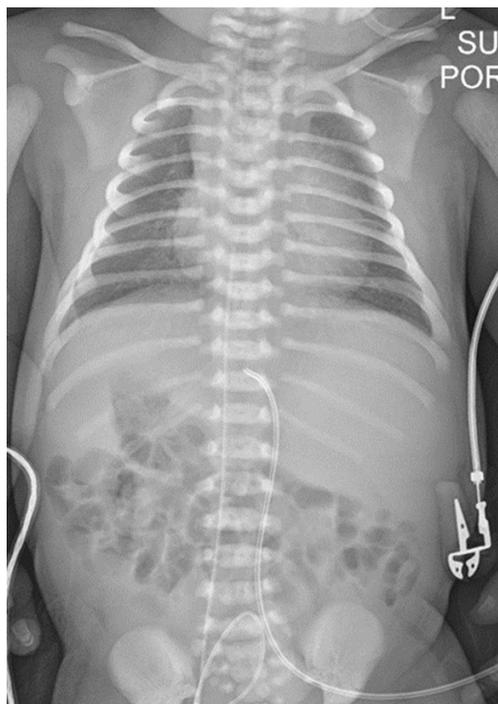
Portable chest x-ray at 1 hour after birth.
